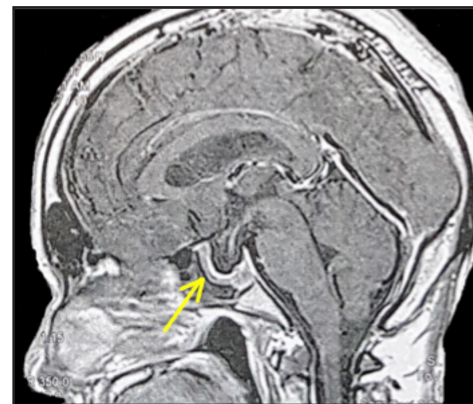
Cranial MRI with contrast, midsagittal view. Note expansion of the pituitary fossa with crescent shaped hypoenhancing soft tissue material (arrow).
